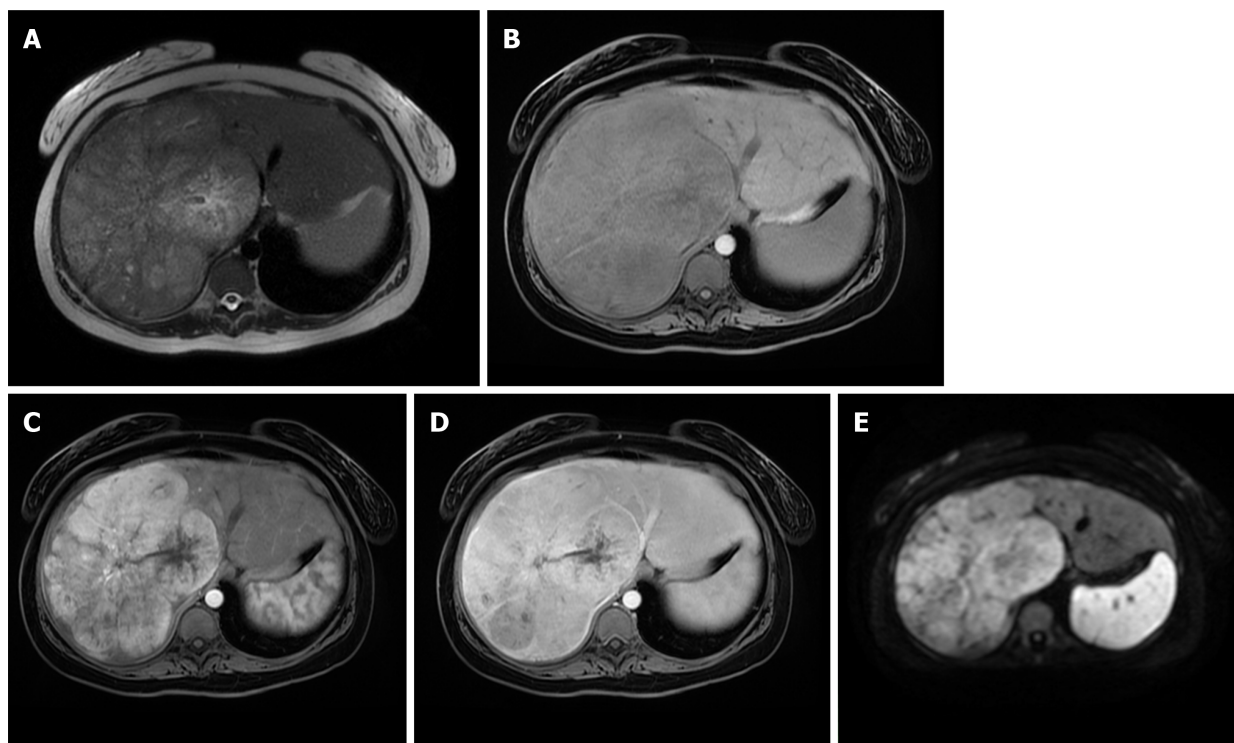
Fibrolamellar hepatocellular carcinoma in 23-year old woman without chronic liver disease. A: Axial T2-weighted image shows large heterogeneous mass occupying almost whole right liver lobe; B-E: The tumor is hypointense on T1-weighted FS image (B), hypervascular on arterial phase (C) with washout in parts of the lesion on portal venous phase (D) and diffusion restriction (E).
